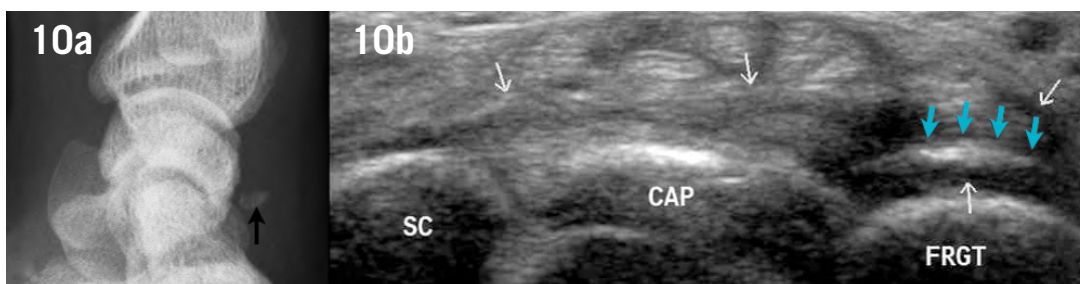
Lateral radiograph a) and ultrasound in axial plane b) show bony avulsion of the dorsal triquetrum (blue arrows) in continuity with dorsal scaphotriquetral ligament (white arrows). SC=scaphoid, CAP=capitulum, FRGT=osseous fragment (avulsion).
